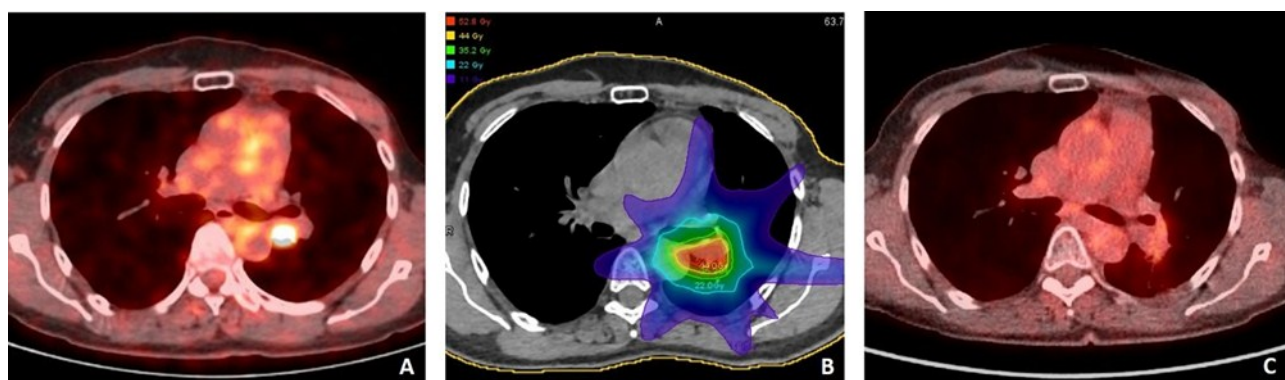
Pre-Radiotherapy PET/CT showed a SUV of 5.5 (Plate A). Stereotactic radiotherapy was performed with 44 Gy delivered in eight fractions (5.5 Gy/day, daily), prescribed at an isodose of 80% of the PTV (Plate B). Restaging PET/CT showed a complete response (Plate C).
